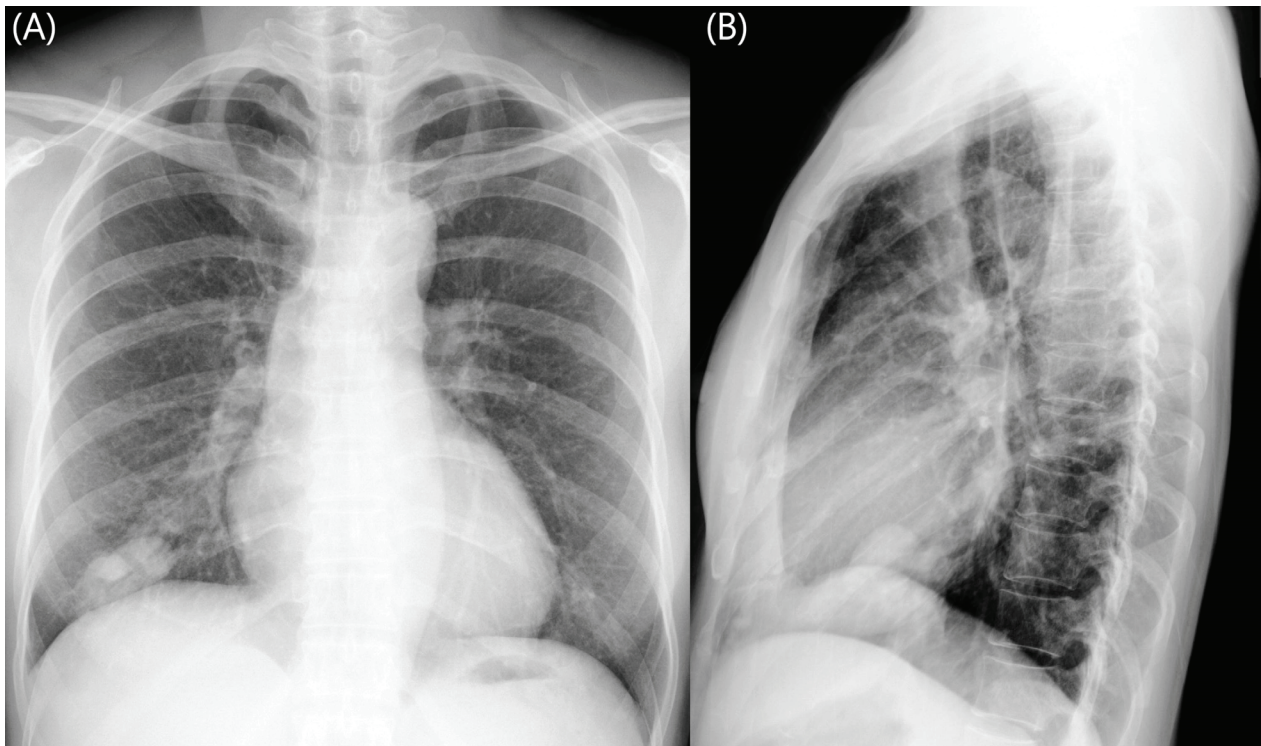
Chest radiography. Posteroanterior (A) and lateral (B) views showed a lobulated soft tissue opacity in the anterobasal segment of the right lower lobe.
